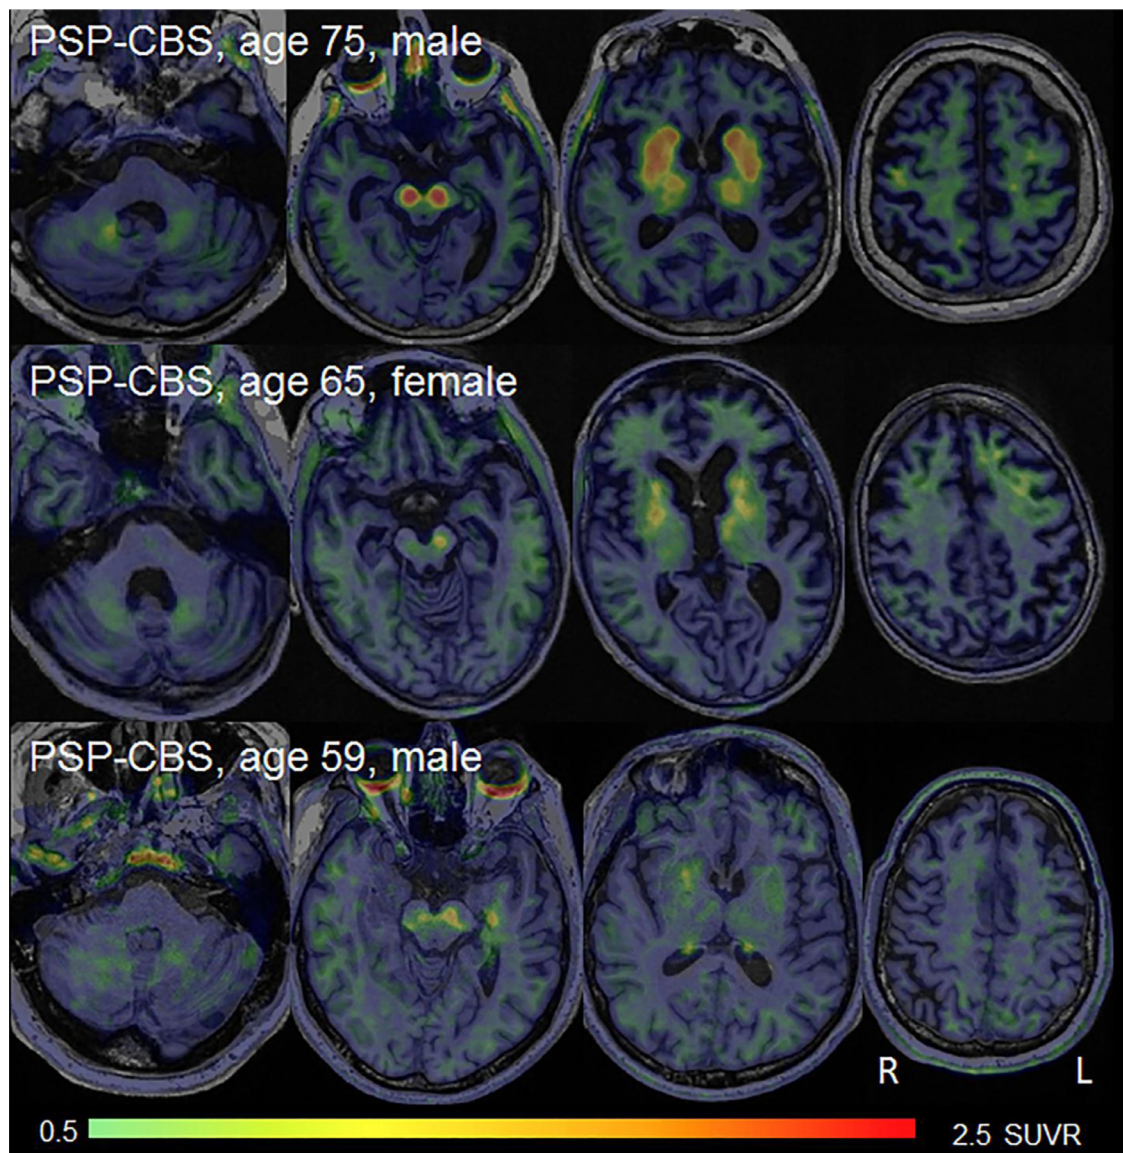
Flortaucipir SUVR images for the three PSP-CBS patients.
